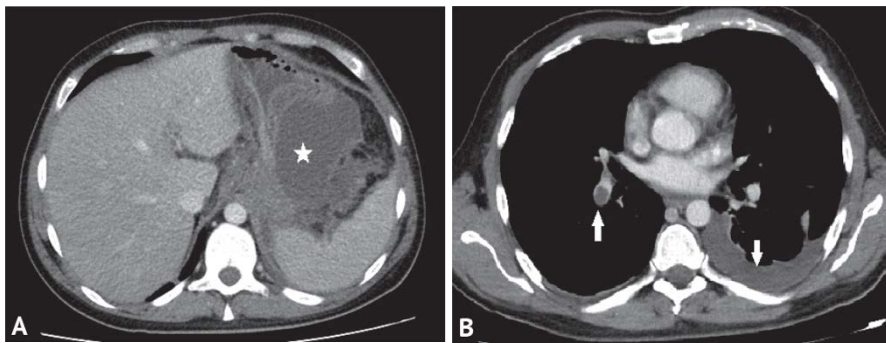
Computed tomography of the chest and abdomen with contrast enhancement, axial projections. Formation of circumscribed fluid accumulations in the parapancreatic and paragastric space (marked with an asterisk in Fig. 2A). In the lumen of the right lower lobe branch of the pulmonary artery, multiple contrasting defects (thromboemboli) and left-sided hydrothorax (marked with an arrow, Fig. 2B) are determined
